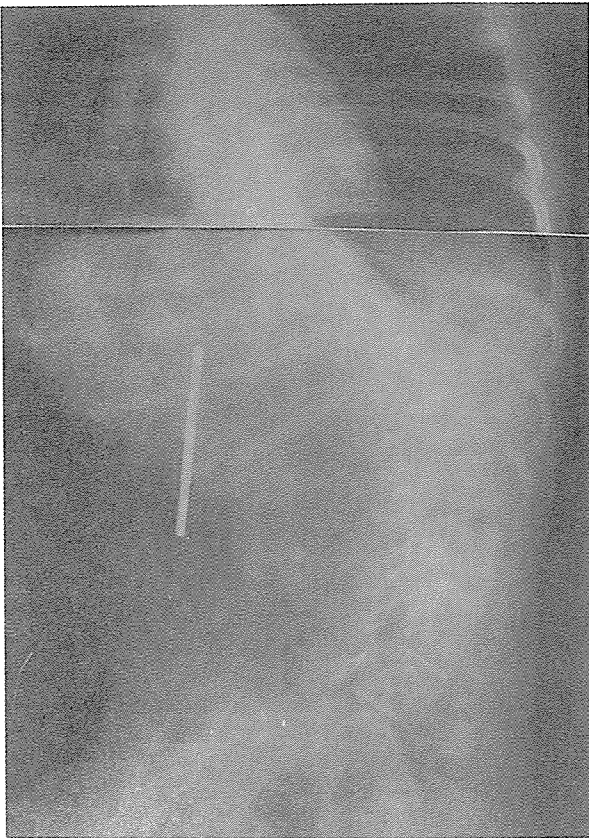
Preoperative X-ray and CT scan of a twenty six years old female with paralytic scoliosis.
